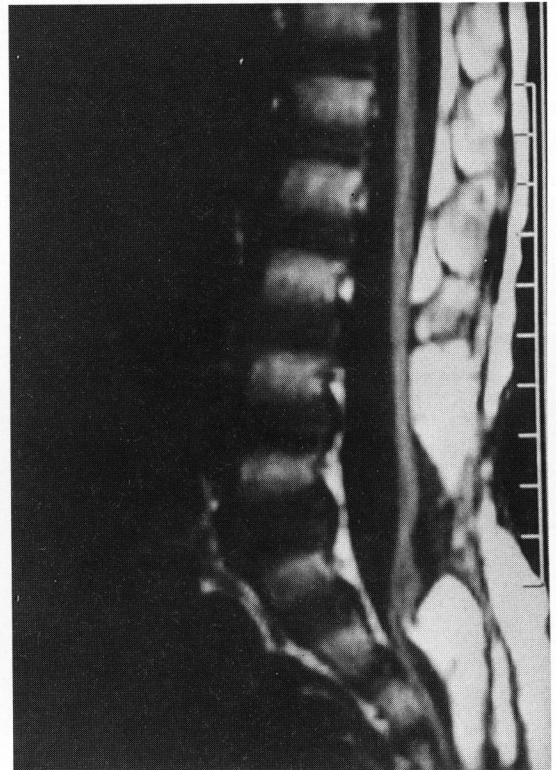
A T1-weighted magnetic resonance image taken at 3 years after surgery shows a low lying conus. The previous meningocele sac and the dorsal cyst disappeared. Though the spinal cord was tethered radiologically, it will be untethered if the clinical findings suggest 'symptomatic tethering'.
